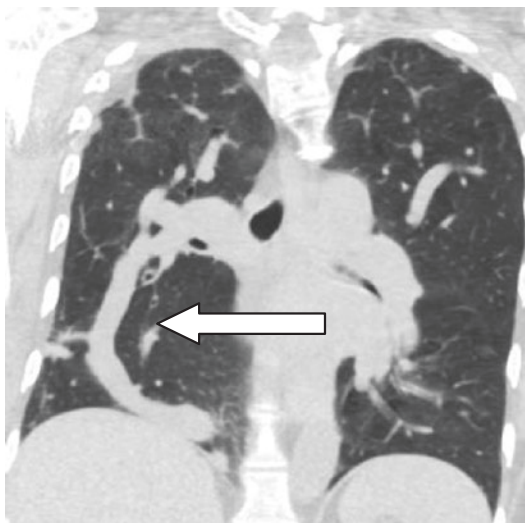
Coronal CT image demonstrates anomalous draining pulmonary vein into the IVC giving an appearance which is likened to a scimitar (arrow)
